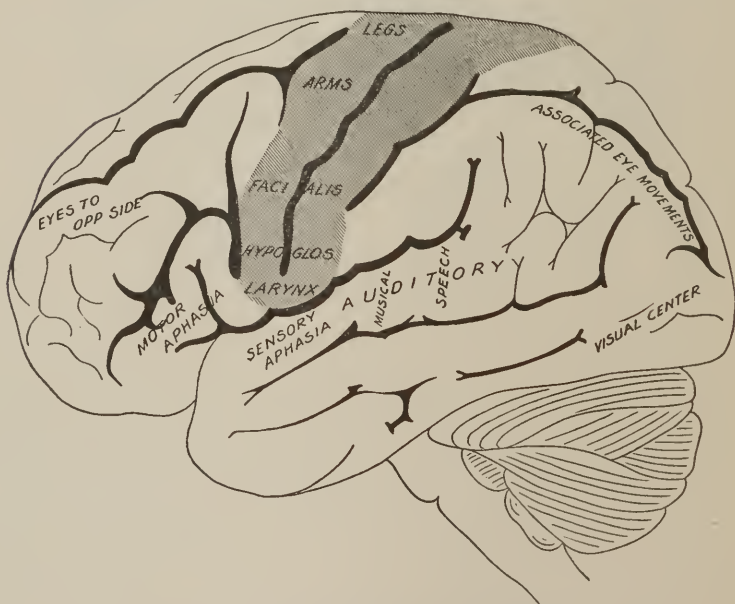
LATERAL ASPECT OF THE BRAIN.
